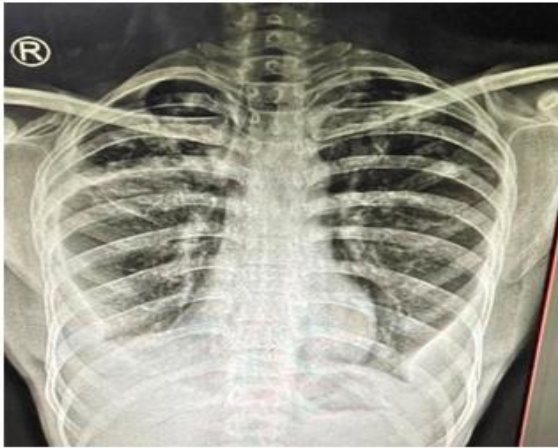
Chest x-ray PA view at the start of antitubercular treatment in the patient showing bilateral loculated pleural effusion with pulmonary tuberculosis.
